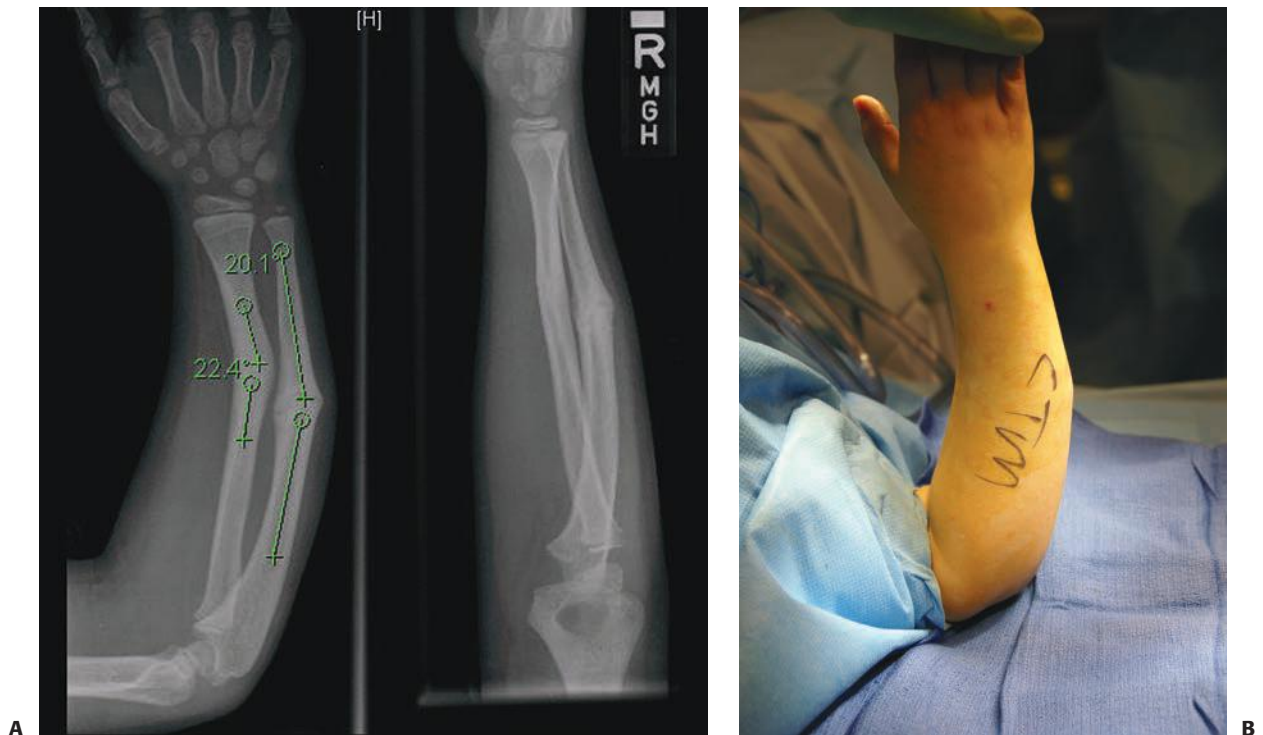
An 8-year-old male who underwent corrective osteotomy for forearm shaft malunion. A: Radiographs demonstrating significant angular malunion. B: Preoperative clinical appearance (dorsal view).
